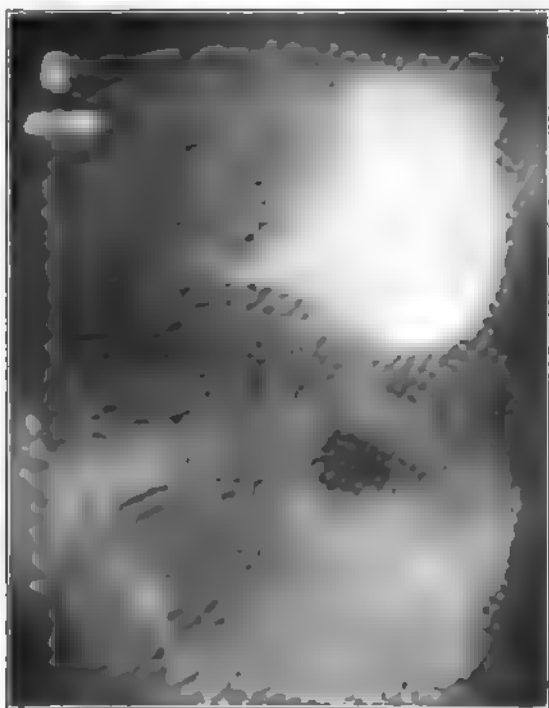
(Case No. A84,287; X-ray No. 21,415.) Male, aged forty-three. Radiogram shows filling defect at pyloric end. No residue after six hours. Operation. Carcinoma of the stomach.
